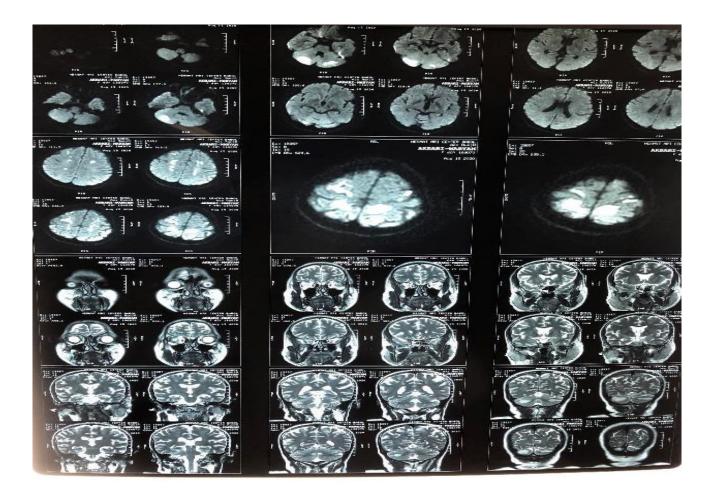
Brain MRI(DWI): show bright signal areas(restrictions) in both cerebellar hemispheres and parieto-occipital(cortical and subcortical)compatible with acute ischemic insult.
